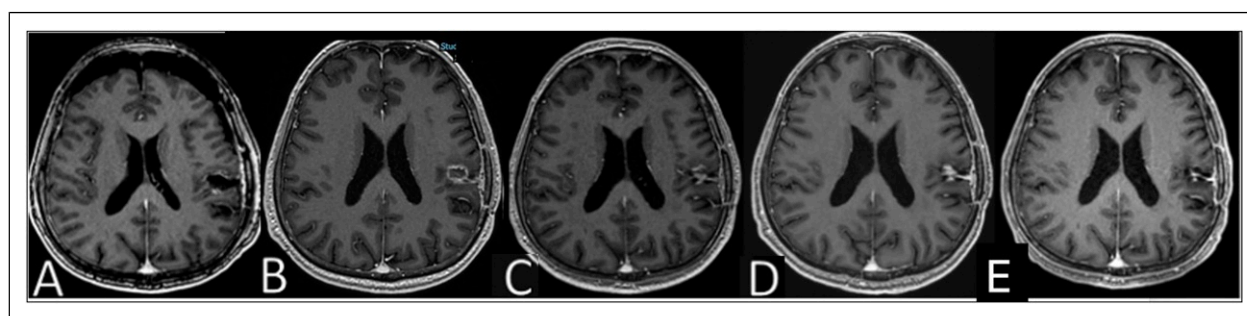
(a) The early postoperative axial post-contrast T1-weighted image showed a peripherally reactive enhancing resection cavity without tumor. (b) At the 3-month follow-up after starting immunotherapy, the T1-weighted image showed increased parenchymal edema around the resection cavity, new irregular contrast enhancement at the cavity level, there is no evidence of increased perfusion on the cerebral blood volume (CBV) map, indicating pseudoprogression. (Hypoperfusion could not be evaluated as a definite sign of recurrence). (c) At the 6-month follow-up, enhancement was visible within the cavity without peripheral edema. After 6 weeks, there is no difference in the findings except for the regression of the millimetric restricted diffusion foci observed in the immediate anterior-superior neighbourhood of the resection cavity. (d) At the 9-month follow-up, the enhancing part within the cavity was slightly highlighted. (e) At 24 months, there was significant regression of abnormal contrast enhancement within the central portion of the surgical bed.
